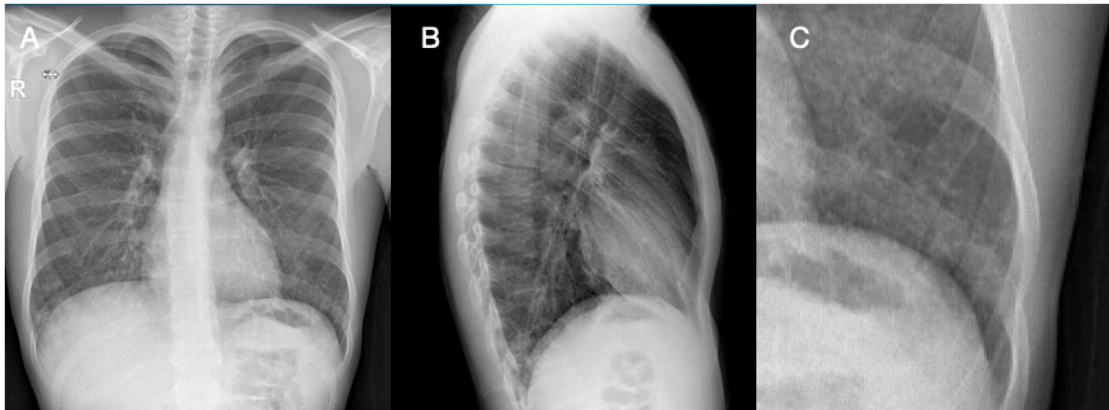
(A-B) Chest x-ray (f/p) suggestive for bronchiectasis in both lower lungs. (C) Close-up of the bronchiectasis of the left lower lung.
